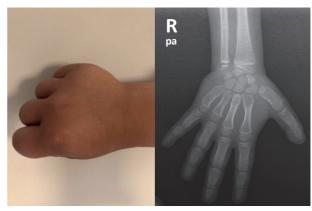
Brachymetacarpia of the fourth and fifth metacarpals, confirmed by hand radiography.
